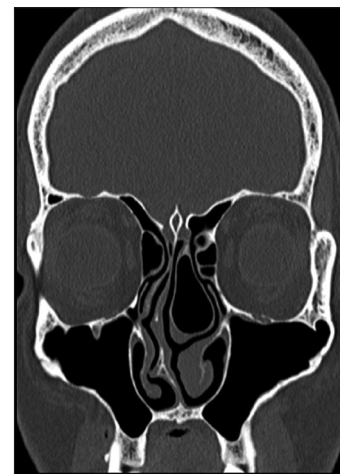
Intranasal CT scan of a patient with severe septal deviation, contact point between septum and right inferior turbinate and left middle turbinate conchae bullosa
